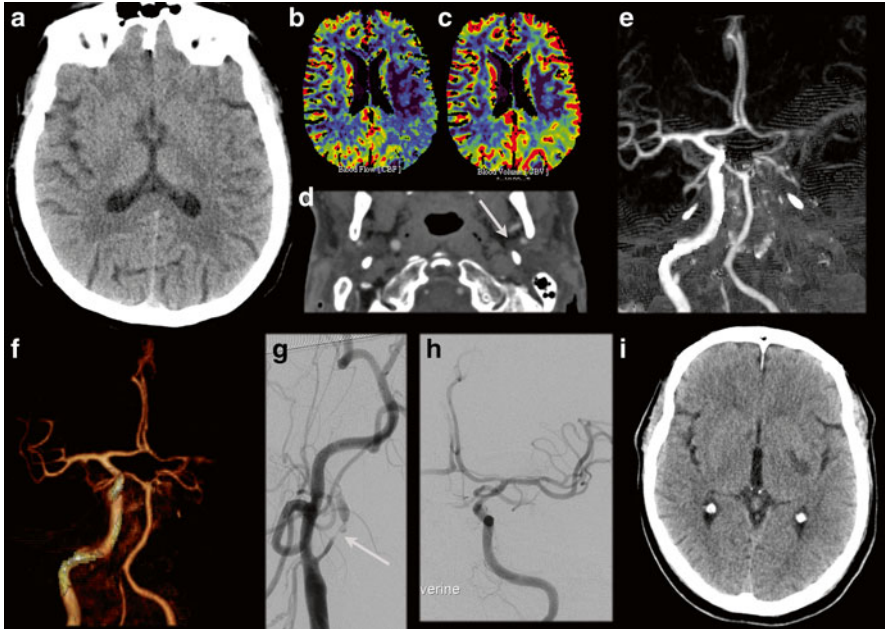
A 62 y/o male patient presented with a right-sided hemiparesis. NECT shows a slight hypodensity and faint loss of gray-white matter differentiation at the posterior border of the left lentiform nucleus (a) and i.v. rTPA was given with initially good clinical recovery. However, the hemiparesis recurred and at that time a VPCT (b: CBF, c: CBV) and CTA were performed. The VPCT shows CBF/CBV perfusion mismatch with increased MTT (not shown). Coronal MIP (e) and VR (f) of the CTA show occlusion of the left internal carotid artery (d, source image) from the bifurcation with an occlusion of the left MCA. The patient went on for DSA and intra-arterial recanalization of the left carotid bifurcation stenosis (g) and subsequent thrombectomy of the left MCA thrombus. A good recanalization was obtained (h). Follow-up CT 1 day later shows a lacunar infarction in the left lentiform nucleus (i), but no other signs of ischemia in the left MCA territory. Initially there was some residual motor deficit, but at discharge there was no neurological deficit
